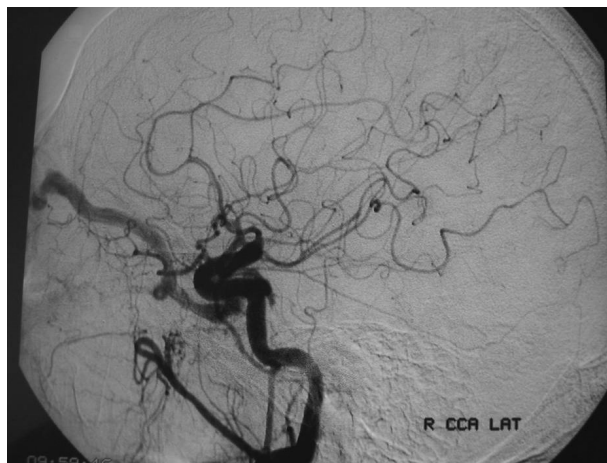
C: Cranial MRI and angiography examinations detecting fistula
